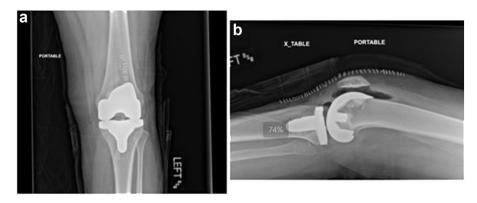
Case 2 postoperative x-rays with (a) AP and (b) lateral views showing total knee arthroplasty in good alignment.
